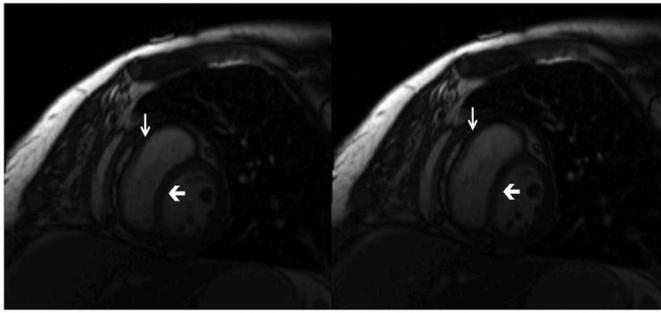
Cardiac MRI Septum (thick arrow) is bowed during systole and flattened during diastole, representing the “septal bounce”, a paradoxical interventricular septal movement during early diastole where the septum first moves toward the left ventricle (left panel) and then away from the left ventricle (right panel), a finding consistent with constrictive pericarditis. Also seen is the thickened pericardium (thin arrow).
